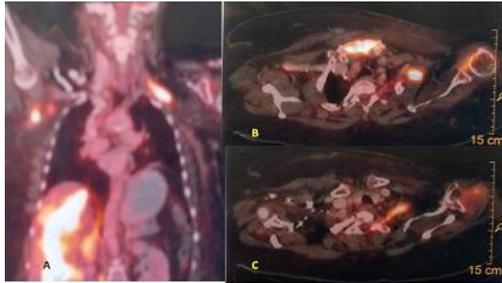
FDG PET image (A) showing FDG avid lesion in Left brachial plexus and right axilla (B) Showing FDG avid lesion in upper and lower brachial plexus (C) showing FDG Avid lesion in lower brachial plexus
